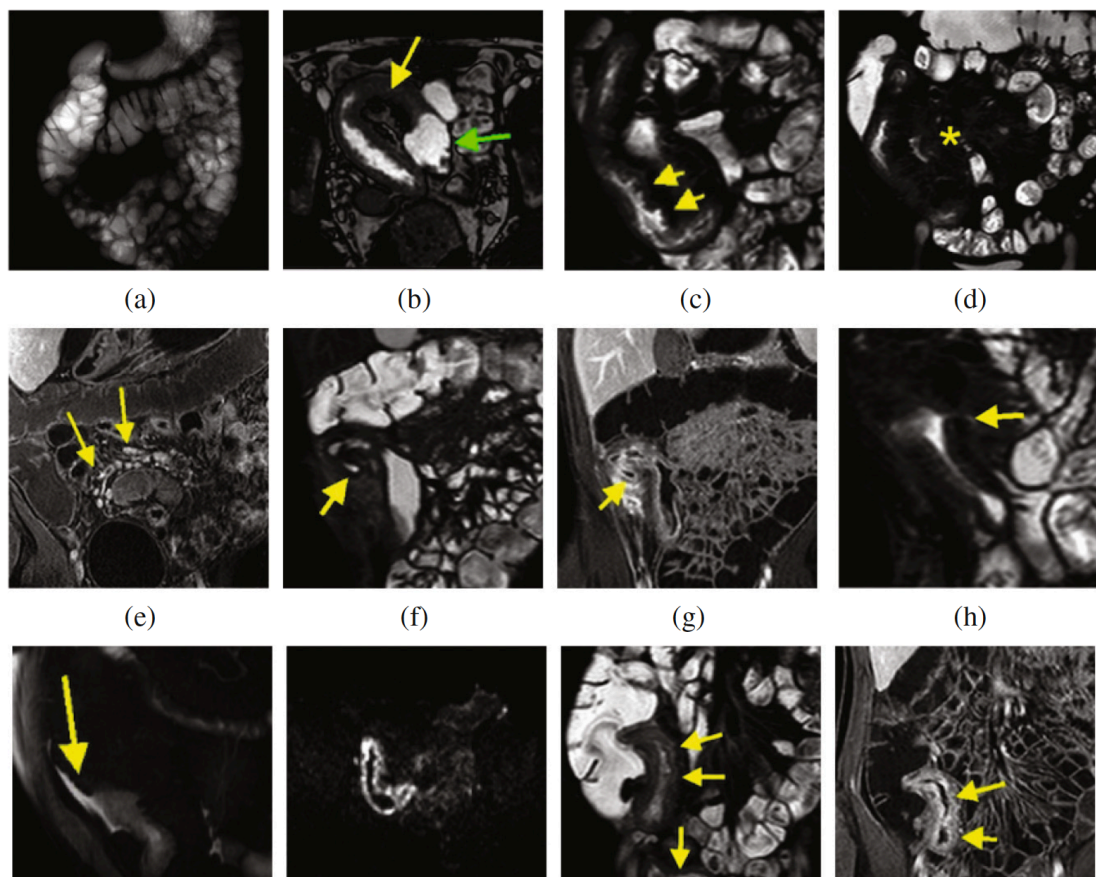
E-MRI CD Features: (a) HASTE Thick slab: Bowel cleansing and distension;
